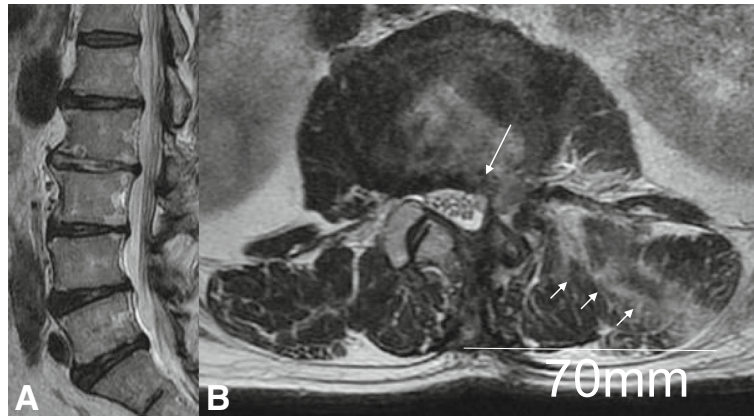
Magnetic resonance imaging demonstrated that all herniated disc fragments had disappeared. a Sagittal view and b axial view. The trajectory of the operation is demonstrated (short white arrow). All herniated disc fragments had disappeared (long white arrow)
